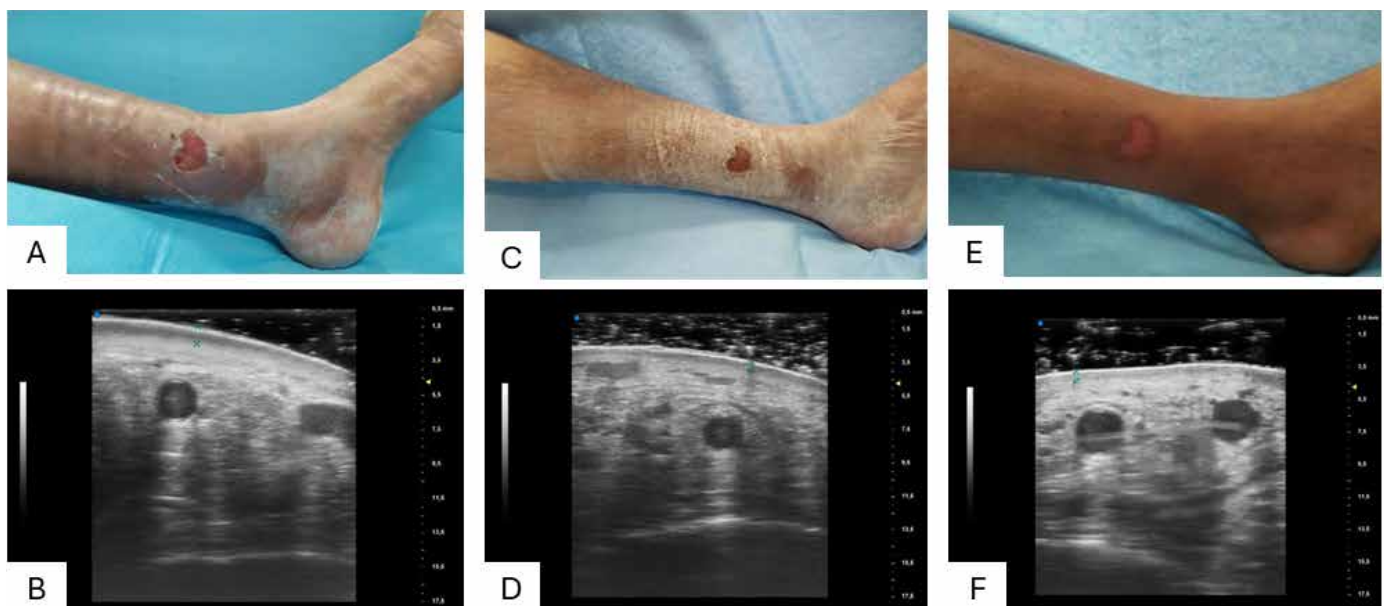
Clinical examination of calf diameter and high-frequency ultrasound (HFUS) assessment of the sub epidermal low echogenicity band (SLEB) in a patient with leg oedema and chronic ulceration. A) Baseline evaluation: calf circumference = 58cm; B) SLEB thickness = 1.03mm; C) After four weeks of treatment with zinc oxide bandage: calf circumference = 40.5cm; D) SLEB thickness = 0.53 mm; E) At the follow-up visit: calf circumference= 40cm; F) SLEB thickness = 0.60mm.
